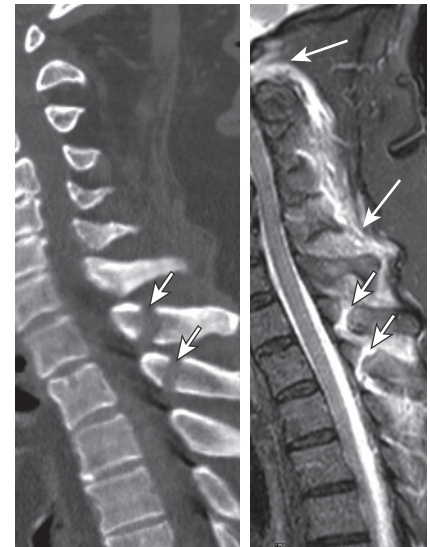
Sagittal computed tomography and sagittal fluid-sensitive magnetic resonance imaging (MRI) of the cervical spine demonstrating multiple spinous process fractures (short arrows). MRI better demonstrates extensive ligamentous injury involving the atlanto-occipital membrane, interspinous ligaments, supraspinous ligaments and ligamentum nuchae (long arrows).
